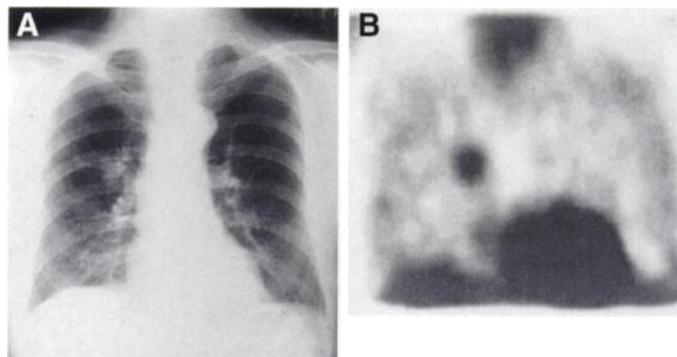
Images from a 74-yr-old woman with lung carcinoma. (A) Plain chest radiograph showing a pulmonary nodule in the right upper lung field. (B) Transaxial ^{201}Tl SPECT image from delayed scan showing a round focal accumulation in the right upper field of the chest.
